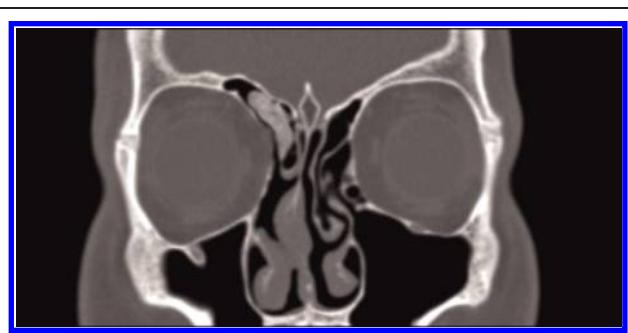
Postoperative computed tomography at 18 months.
